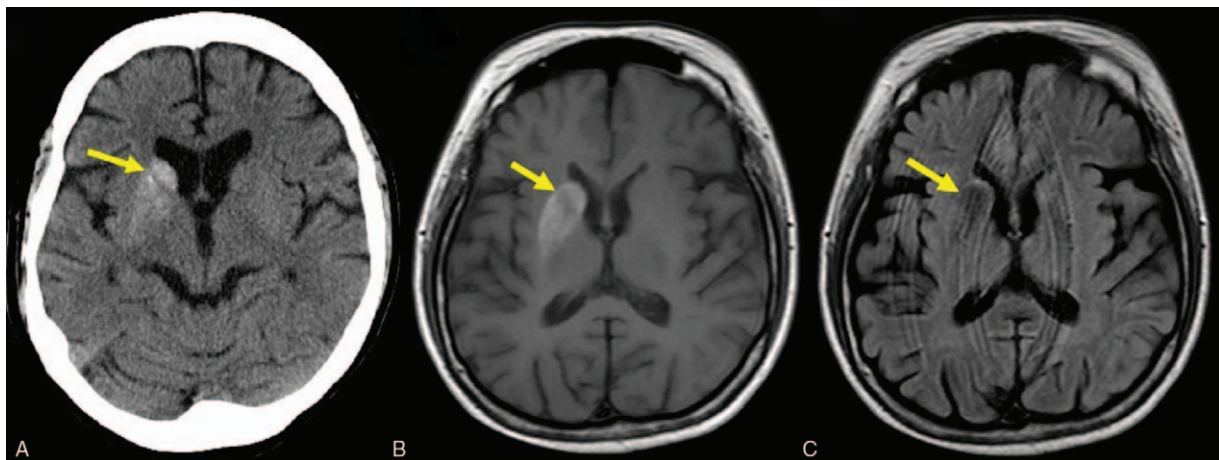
Right caudate nucleus and putamen of brain (arrow). Hyperintensity in brain CT, Hyperintensity in MRI T1-weighted sequence, (c) Hypointensity in MRI T2-weighted sequence.
